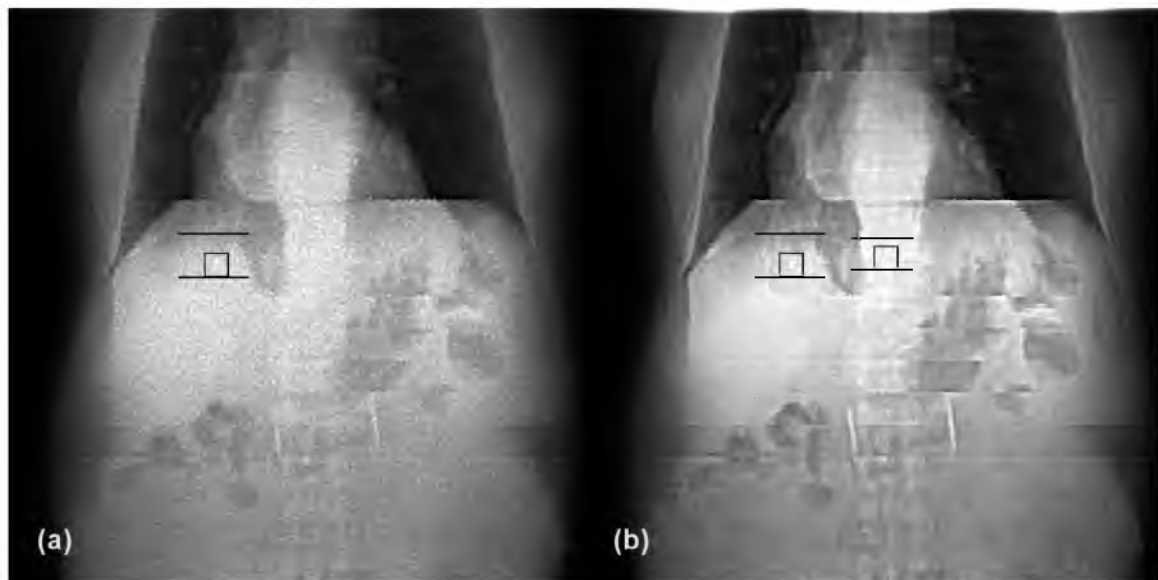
Reconstructed 4D radiograph sequences through a liver tumor patient breathing cycle using (a) a 230 MeV proton pencil beam, (b) a 330 MeV proton pencil beam, and (c) a 500 MeV/nucleon carbon ion pencil beam. Please note: These sequences must be visualized using a PDF reader software with sequence display capabilities such as Adobe Acrobat™ in order to fully appreciate the motion.
